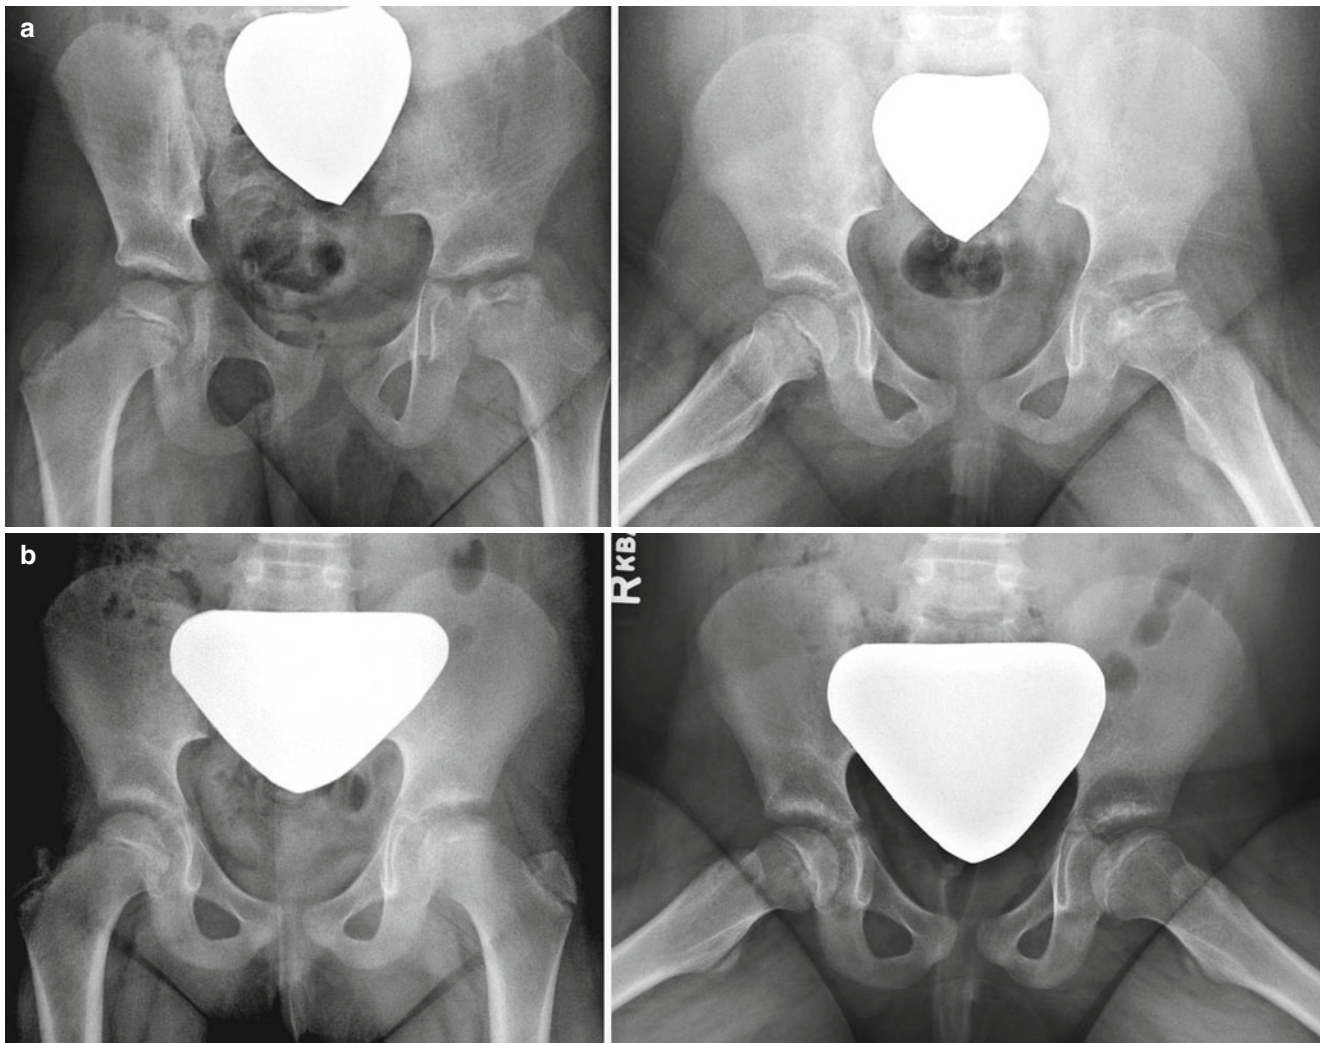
Five-year and 7-month-old female with left hip pain for 1 month. (a) AP pelvis and frog-leg lateral radiographs obtained at mid-fragmentation stage showing lateral pillar B hip. This patient was treated symptomatically and with activity restrictions (no running or jumping).
